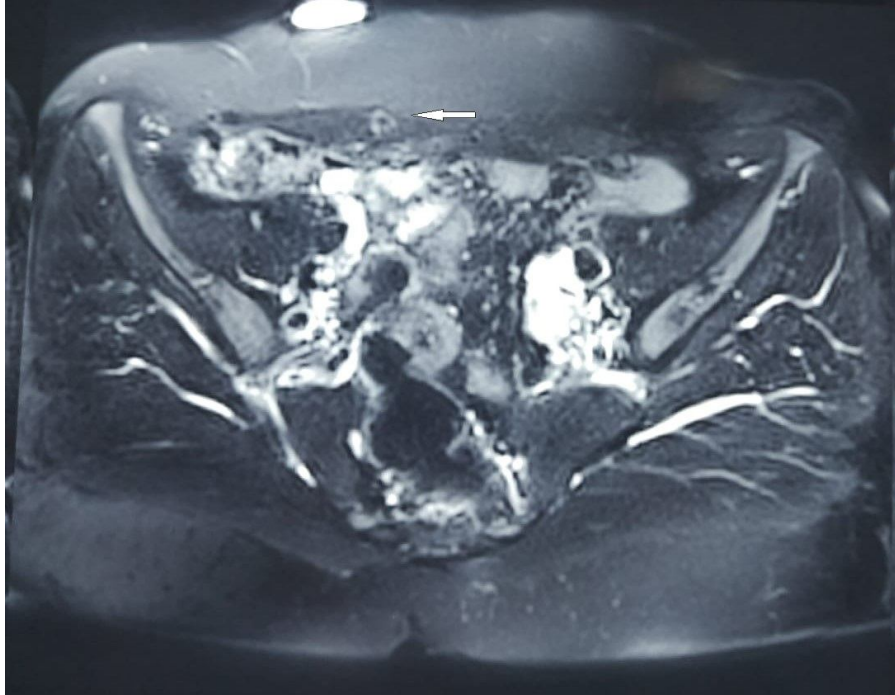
image of endometriotic image on MRI
